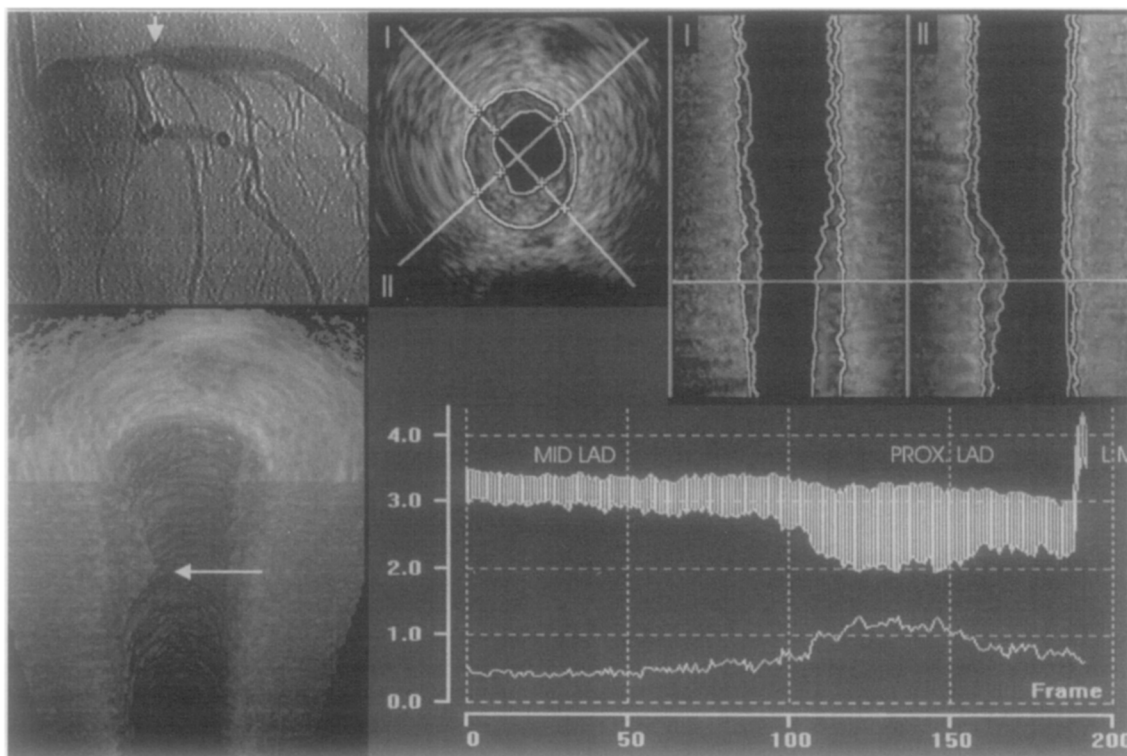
Proximal stenosis of left anterior descending coronary artery (LAD) (left upper panel) assessed by new system for quantitative analysis of three-dimensional intracoronary ultrasound images.^{3,4} Cross-sectional ultrasound images were reconstructed in two perpendicular longitudinal sections (I and II, right upper panels) and computerized contour detection was performed providing a three-dimensional view (left lower panel) and dimensions of lumen, plaque, and total vessel, calculated from area measurements. Mean diameter measurements (mm) of 200 consecutive ultrasound frames (right lower panel) are displayed, with plaque shown as white area between total vessel and lumen diameter. Note reduction of total vessel diameter from distal reference (mid-LAD) to target stenosis. Arrowheads in three-dimensional view and angiogram indicate site of stenosis, which is also displayed in cross-sectional ultrasound view (mid-left upper panel). LM, Left main coronary artery; PROX, proximal.
